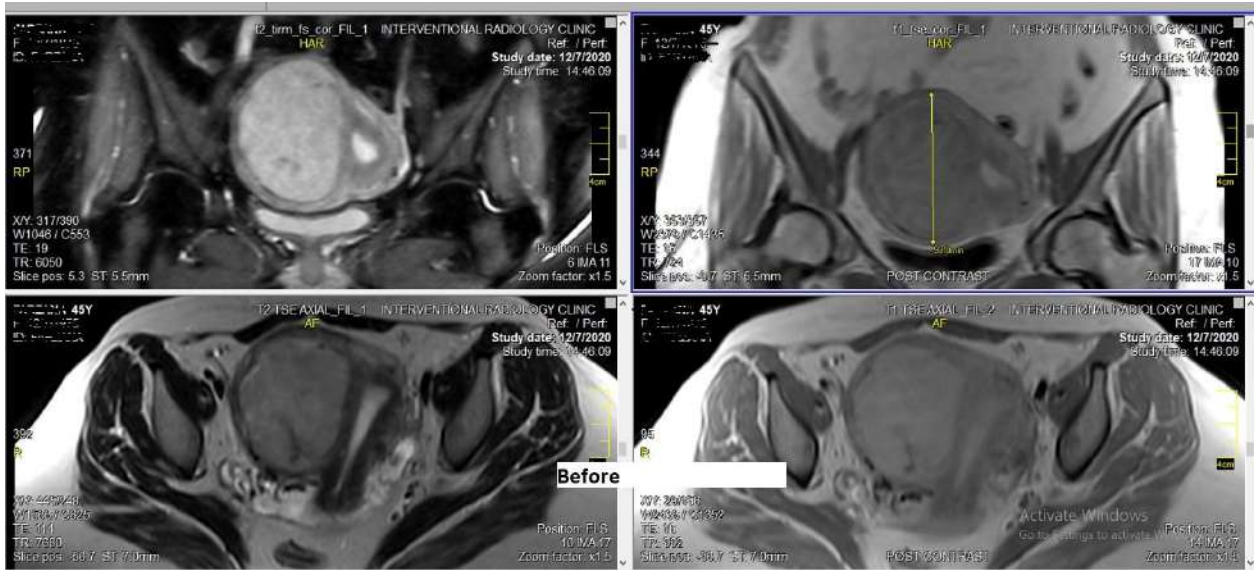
a: MR images showing a solitary large right lateral wall fibroid.
